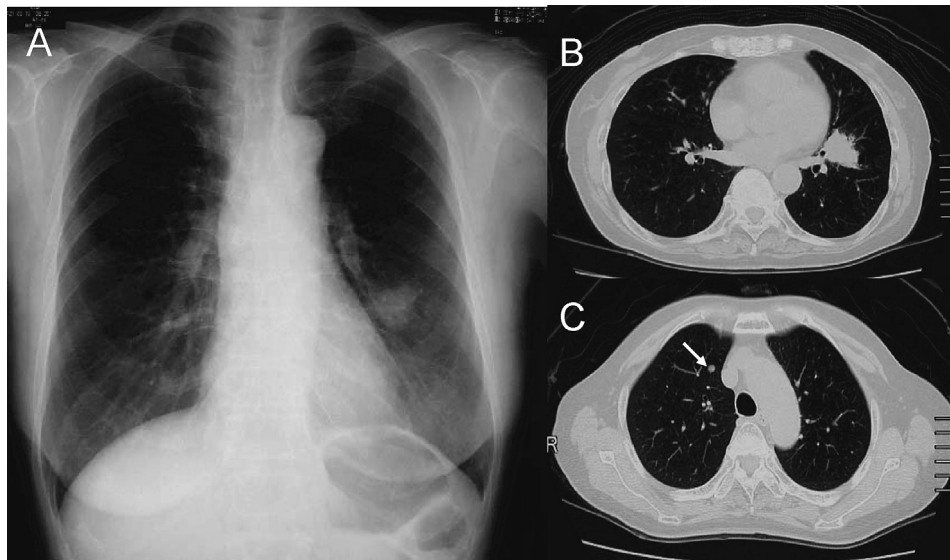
A Chest radiograph on admission shows a tumor shadow in the left lower lung field, but the right lung tumor is unclear. B, C Chest computed tomography (CT) shows a well-defined, small nodule in the right S3 (*arrow*) and a 3-cm-diameter tumor with ill-defined margins in the left S8.
